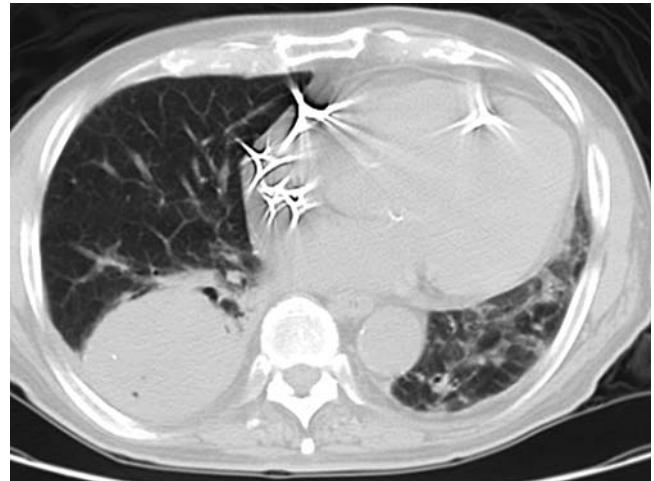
CT of chest. This rather large pulmonary blastoma occupies the superior segment of the right upper lobe in a patient with a pacemaker. Large size is a major feature of pulmonary blastomas.
